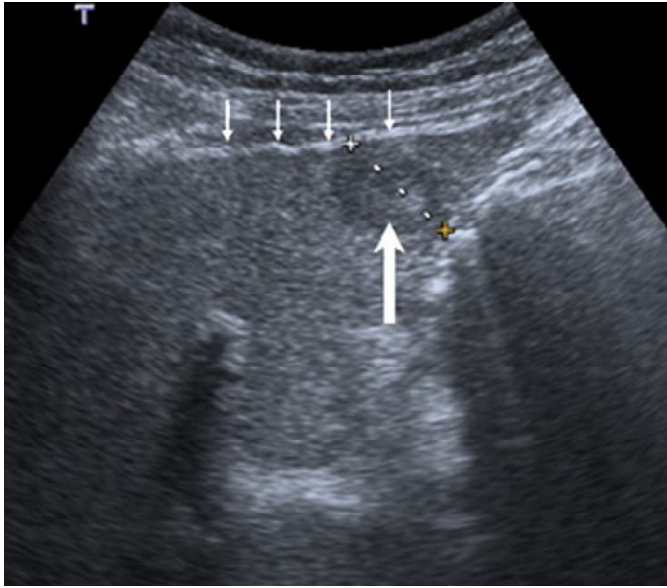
B-mode ultrasound image of a patient with cirrhosis shows irregular liver surface and a hypo-echoic lesion. (Goyal et al. 2009)
